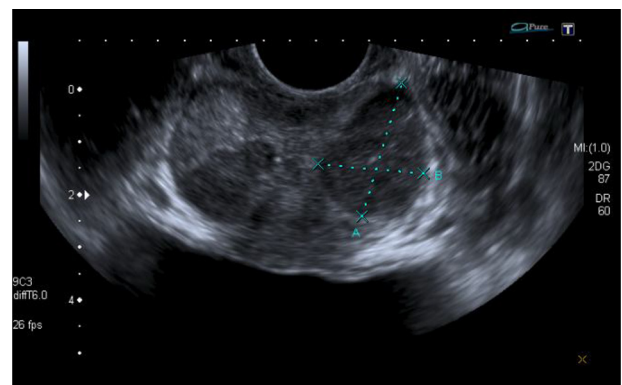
Ultrasound showing an enlarged prostate with nodular lesions.
